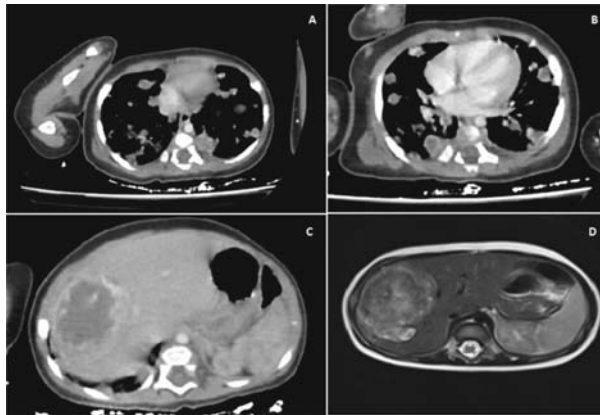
Bilateral pulmonary nodules on computed tomography (a and b); hepatic mass in right lobe of liver on computed tomography (c), and in magnetic resonance imaging (d).
